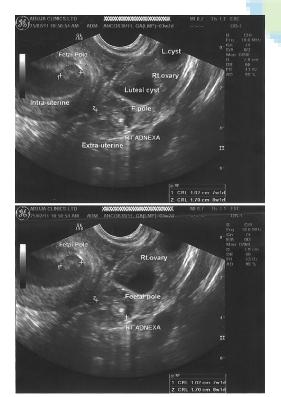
Endovaginal ultrasound scan showing the intra and extra-uterine gestation and right luteal cyst
